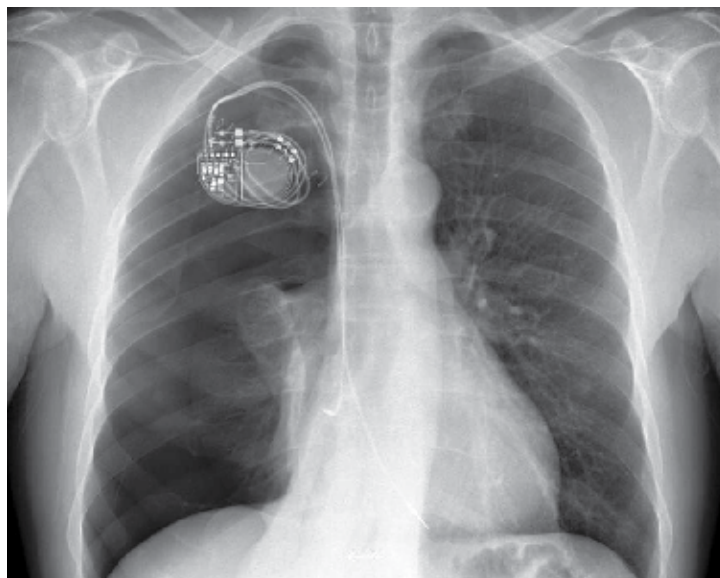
Chest X-ray showing complete right pneumothorax, which was treated with a chest tube.
